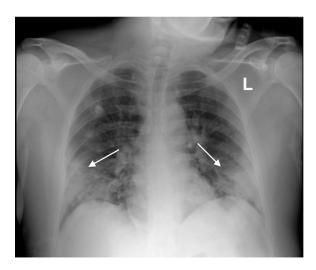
Frontal chest radiograph done before intubation, it demonstrate interval resolution of the right middle lung zone opacity and progression of lower zone opacity.
